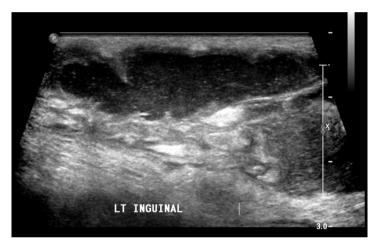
Ultrasound groin shows multiple lymph nodes with collection at subcutaneous tissue 7.7 ml of right groin area.
